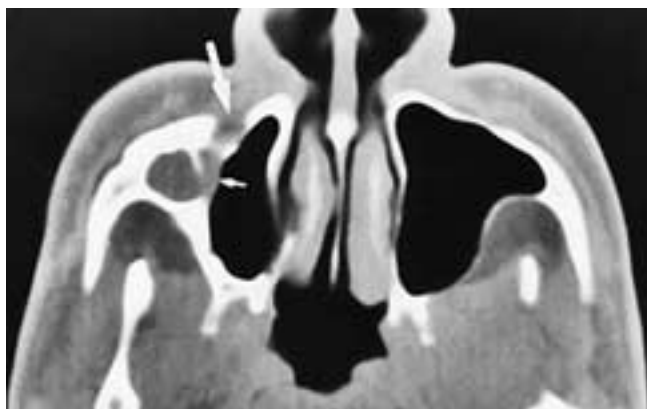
Axial CT scan shows an anterior Caldwell-Luc defect in the right maxillary sinus wall (*large arrow*). There is an expansile mass in the lateral portion of the right antrum (*small arrow*). This patient had a postoperative antral mucocele.
